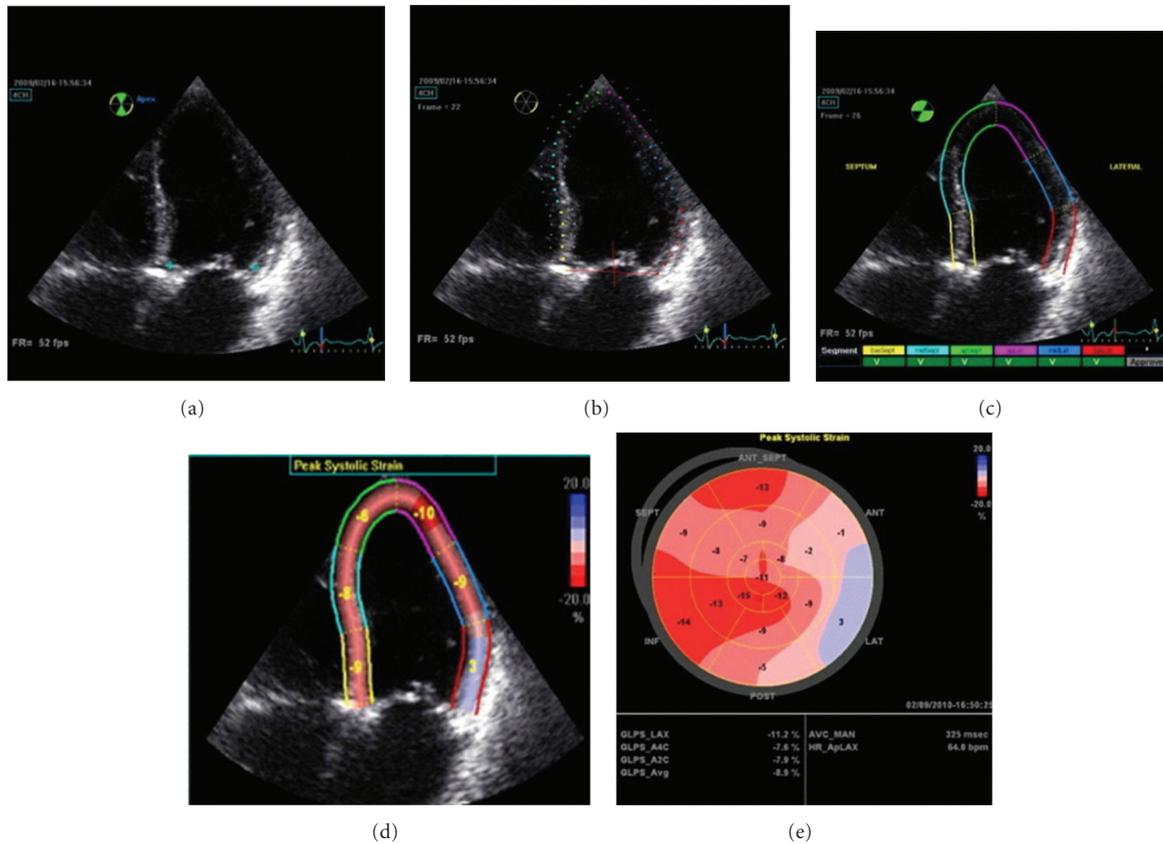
Steps involved in the sequence of Automated Functional Imaging (AFI) analysis and conventional analysis using the apical four chamber view (AP4C). (An example, see also text.) (a) Two points have been applied on both sides of the Mitral valve. The apical point has yet to be placed. (b) Myocardial wall of the left ventricle has been outlined defining a region of interest (ROI), consisting of 3 concentric lines delineating the endocardial and epicardial borders and a midmyocardial layer and end systole is automatically marked by aortic valve closure. (c) ROI is divided into 6 segments and good alignment is confirmed within each segment. (d) Peak systolic strain values of each segment have been calculated by the computer algorithm. (e) Bulls Eye plot presenting segmental peak systolic strain values (17 segment model) and global peak systolic strain values of each view (GLPS LAX: apical long axis; GLPS 4C: apical four-chamber; GLPS 2C: apical 2 chamber) and an overall averaged peak systolic strain value average GLPS.
